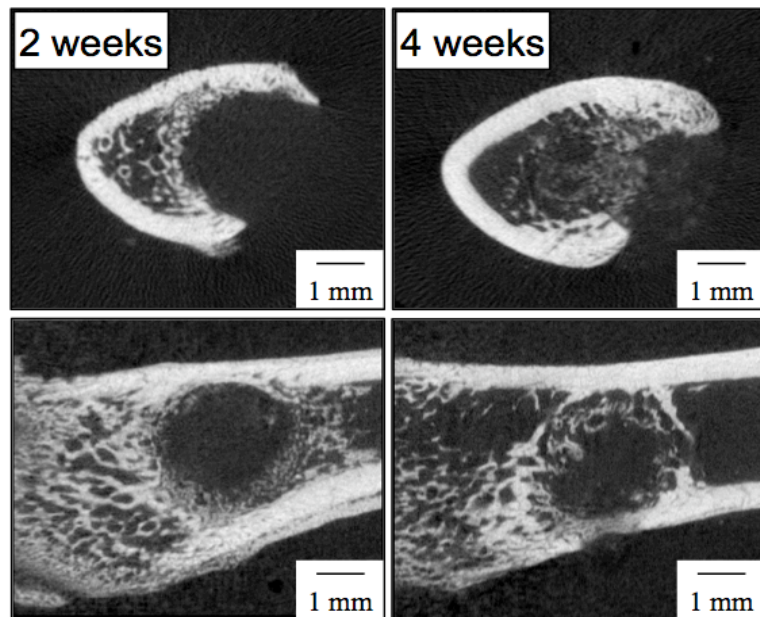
Coronal (top) and sagittal (bottom) μ CT images of injected PUR scaffold in femoral plug defect at 2 weeks (left) and 4 weeks (right) reveal bone ingrowth. The PUR scaffold itself is not radio-opaque.
